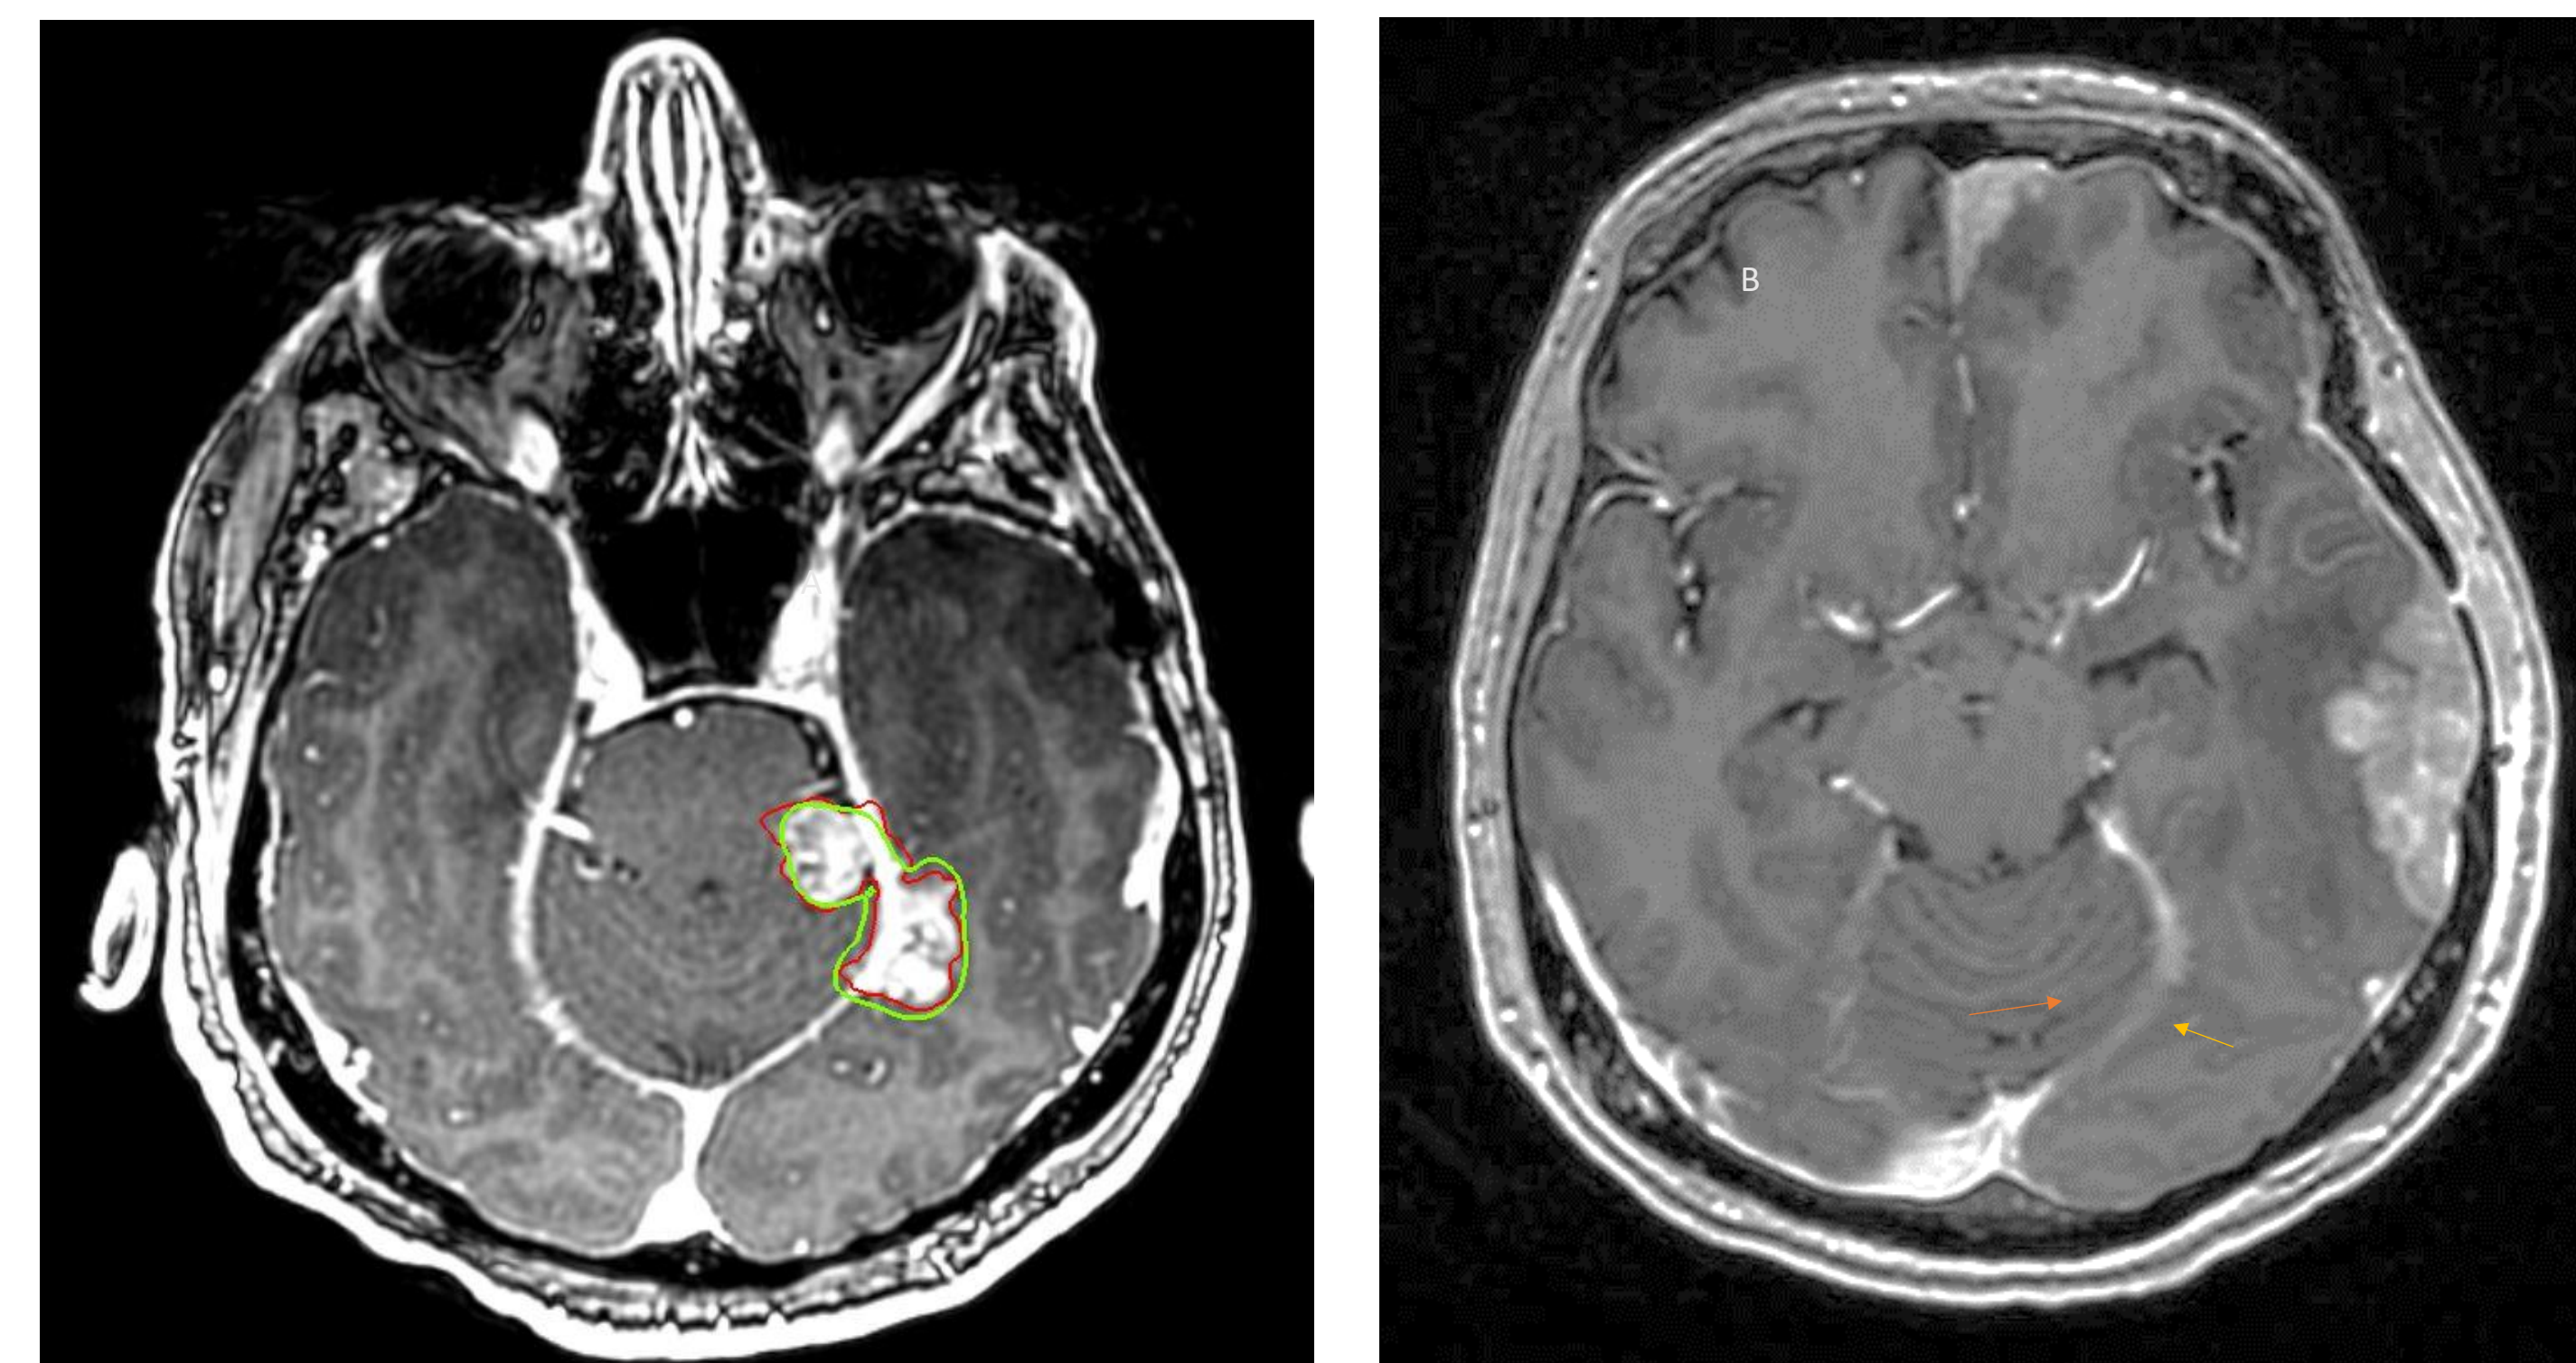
MRI studies of patient # 2.
